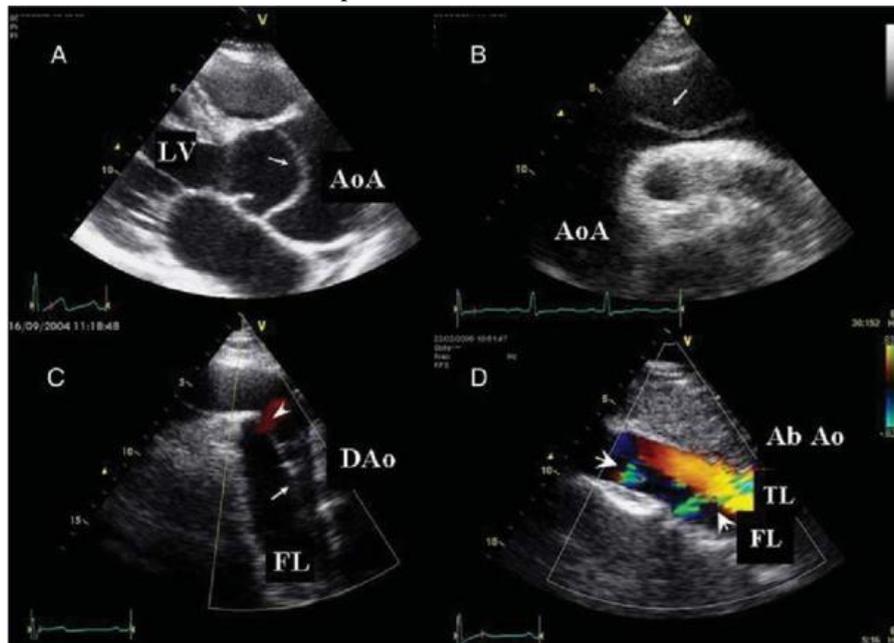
TTE showing: Intimal flap (arrows) and two lumina are visualized in: (A) aortic root, (B) aortic arch and distal ascending aorta, (C) proximal descending aorta (arrowhead shows the entry tear), and (D) dissection of abdominal aorta. Color Doppler helps to identify the true lumen (TL). Arrowheads signal secondary communications.
